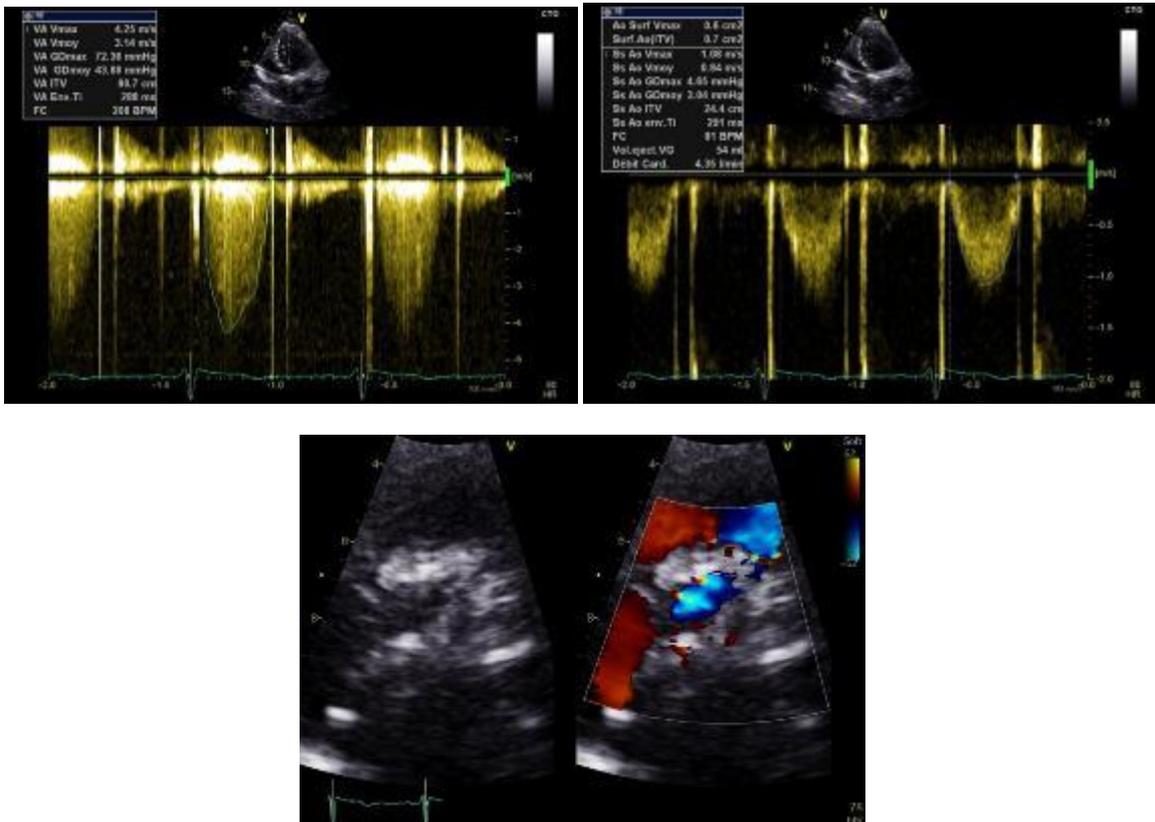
Transthoracic echocardiography showing a mechanical prosthesis with a blocked leaflet, a transprosthetic gradient of 43 mmHg, Vmax of 4.2 m/s, and an effective orifice area of 0.7 cm².
